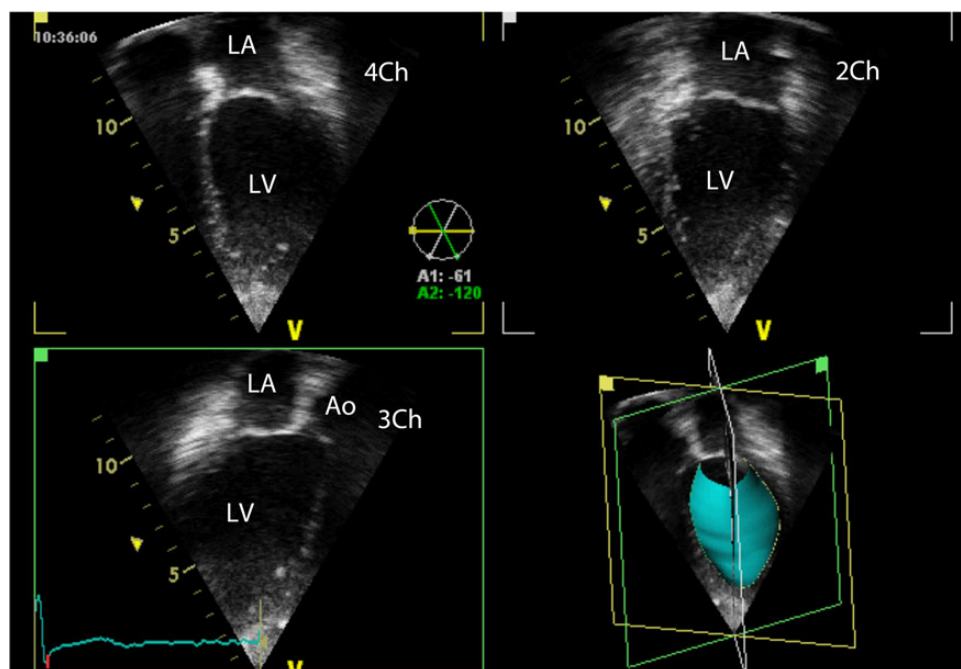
'Triplane' view of the left ventricle. This view permits visualization of the apical four-chamber, two-chamber, and three-chamber views as well as the volume defined by the endocardial border of the three reference planes. LA, left atrium; LV, left ventricle; Ao, aorta.
